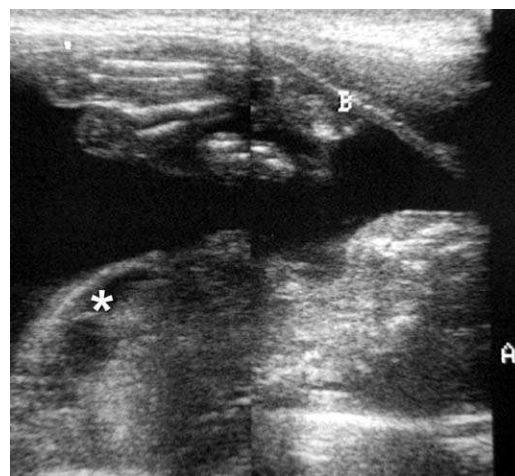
Twin-twin transfusion syndrome shown on a dual-array sonogram. The donor twin (B) is located anteriorly within an oligohydramniotic sac, and the recipient twin (A) is dependent within a polyhydramniotic sac. The recipient is hydropic, with ascites (\*).
